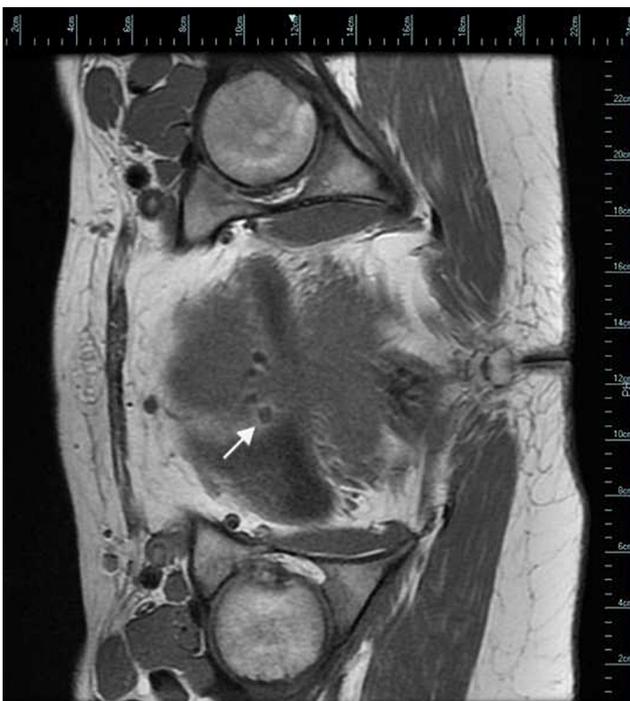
Axial T1-weighted MRI of pelvis. Arrow shows 5×4 mm tubular structure along the anterior serosal surface of the uterus. Note the regularity of the outline of the structure, suggesting a man-made object.
